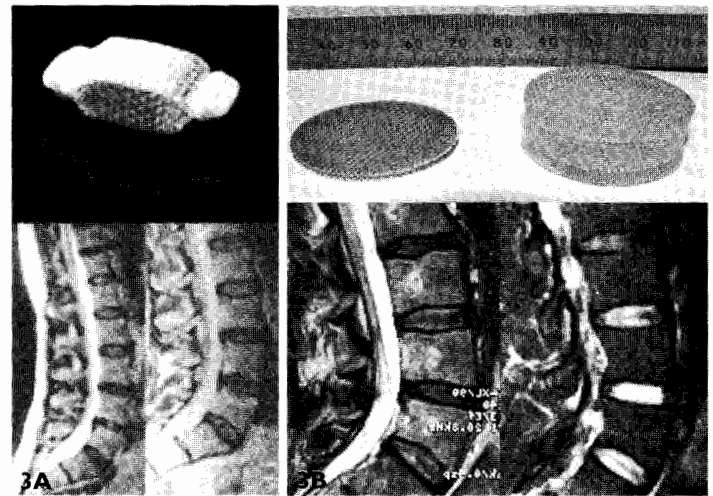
Nucleus Replacement. 3A top: PDN-solo device. 3A bottom: MRI PDN-Dual. 3B, top: Neudisc device. 3B bottom: MRI Neudisc case.
